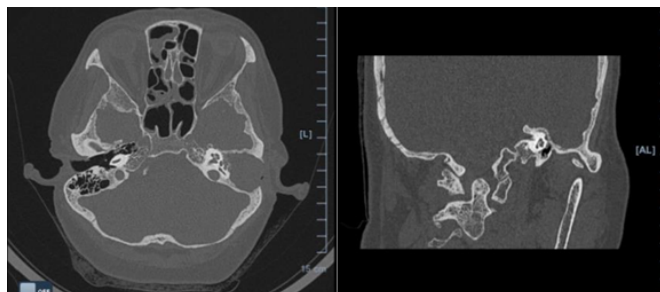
A preoperative axial and coronal CT scan.
